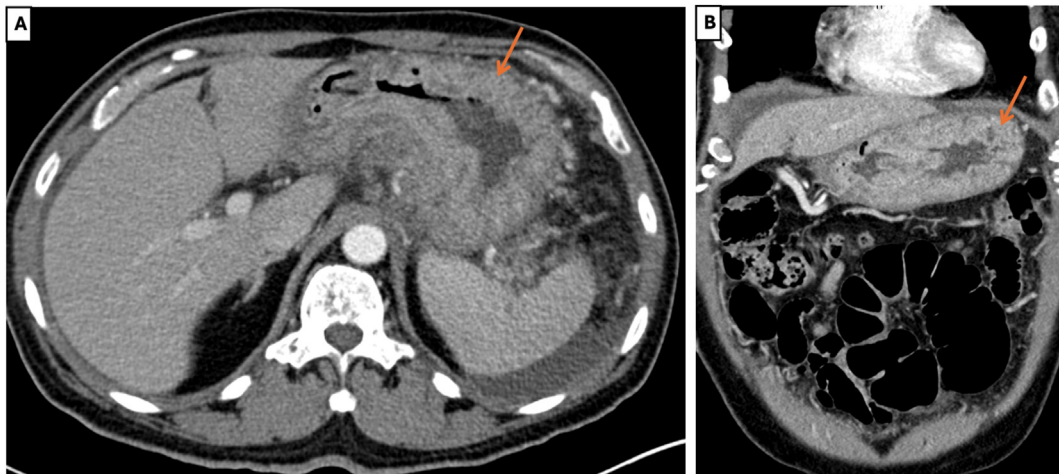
Abdomen and pelvis computed tomography images showing gastric thickening (arrows) from axial (A) and sagittal (B) views.
